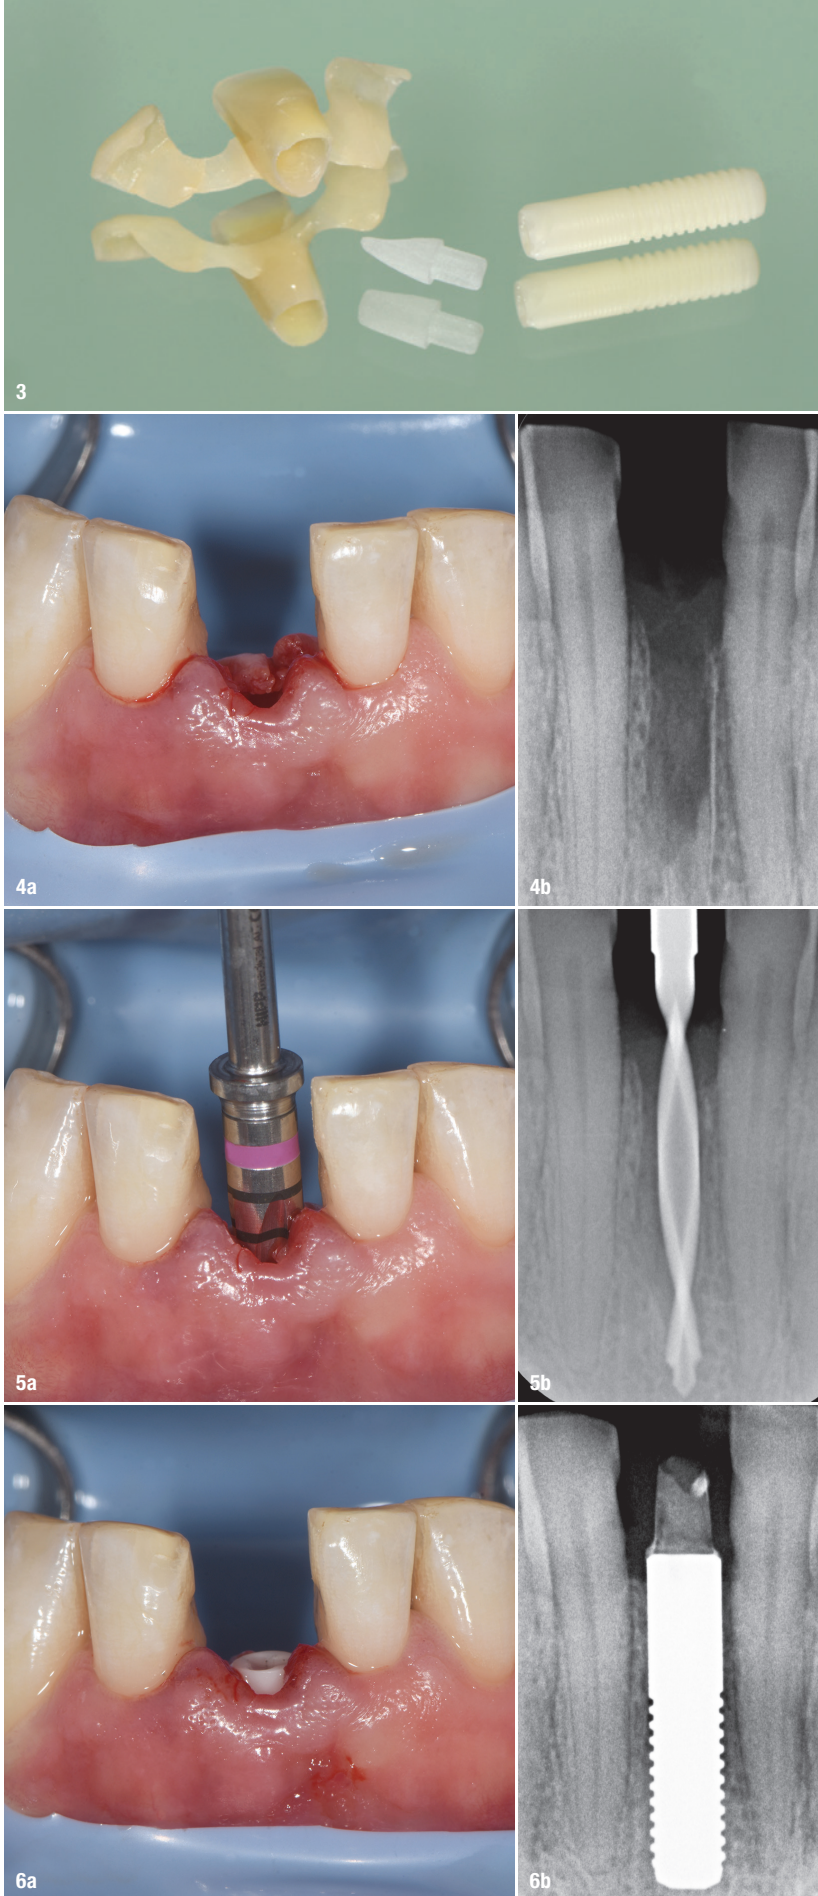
From left: The shell provisional prosthesis with wings to be supported on the neighbouring teeth, the glass fiber post prepared in advance, and the individual narrow-diameter implant. Figs. 4a & b: Frontal clinical view (a) and radiograph after root extraction (b). Figs. 5a & b: Frontal clinical view (a) and radiograph of the osteotomy preparation (b). Figs. 6a & b: Frontal clinical view (a) and radiograph after immediate implant placement (b).
